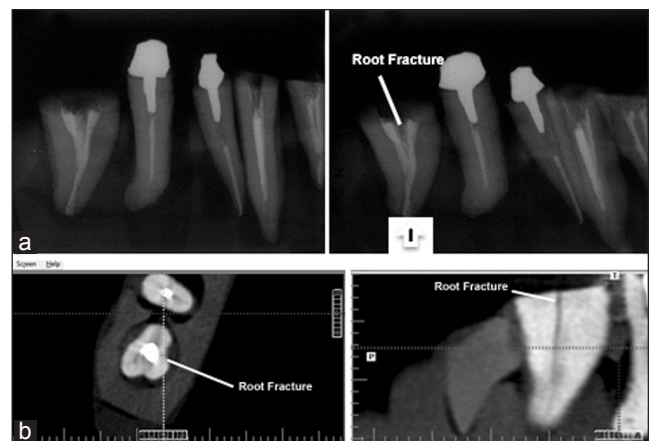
(a) Conventional periapical radiograph using parallax principle. The arrow indicates the tooth with vertical root fracture (VRF). (b) Cone beam computed tomography (CBCT) using i-CAT Vision software. VRF is seen in parasagittal section
